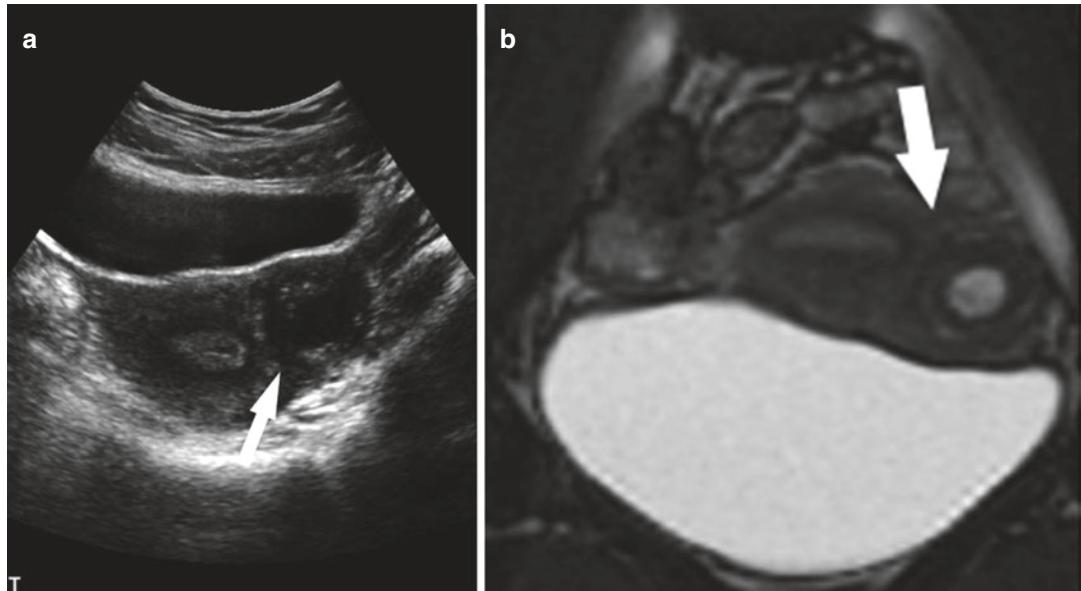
(a) Transabdominal ultrasound in a 36-year-old woman with an estimated gestational age by dates of 7 weeks. Ultrasound shows a gestational sac which is eccentrically located near the origin of the left fallopian tube (arrow). (b) Coronal follow-up T2-weighted MR
